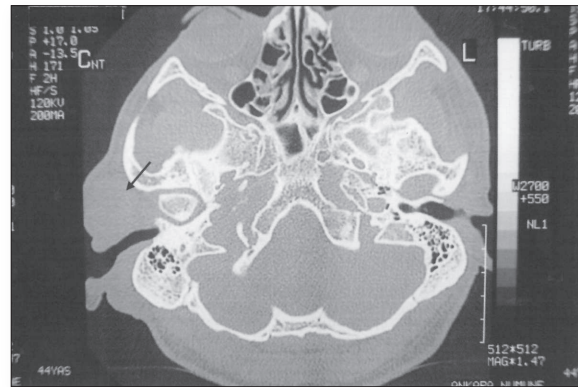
Axial CT scan shows 2×2 cm soft tissue mass in the right parotid region and 1×1.5 cm. of similar mass in the postauricular region.
